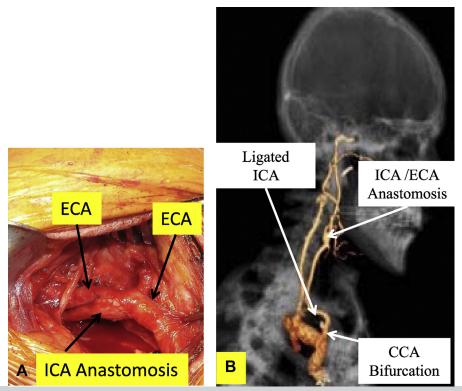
A, Intraoperative photograph showing the internal carotid artery (*ICA*) to external carotid artery (*ECA*) bypass. B, Three-dimensional computed tomography angiography (CTA) detailing the ICA to ECA bypass and ligation of the proximal diseased ICA. *CCA*, Common carotid artery.
